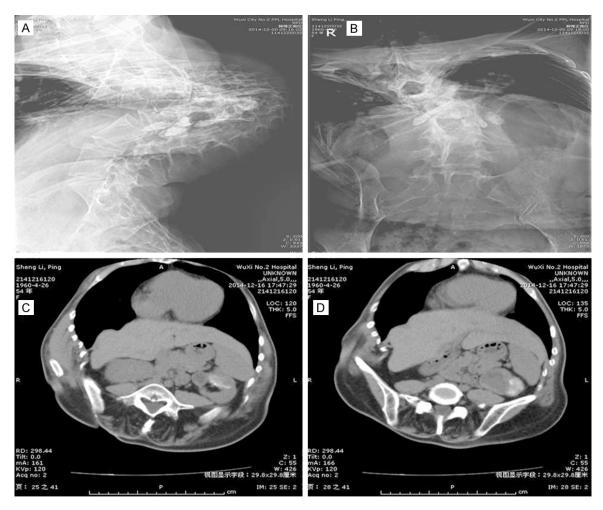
The patient's spine were severe deformed, as a "N" shaped in X-ray examination. (A and B) Computed tomography scan showing a tumor in the left kidney (C and D).
